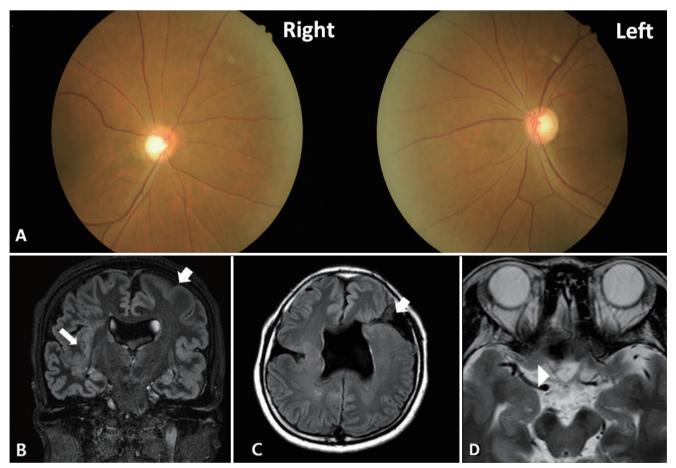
Fundus photo (A) and brain MRI (B-D). (A) Relative disc pallor in the right eye compared to the left. (B) Lissencephaly (thick arrow), gray matter heterotopia (thin arrow) and absent of septum pellucidum on coronal short tau inversion recovery fluid-attenuated inversion recovery MRI. (C) Schizencephaly (thick arrow) on axial fluid-attenuated recovery MRI. (D) Hypoplasia of right optic nerve (arrow head) on T2 axial MRI. MRI, magnetic resonance imaging.
